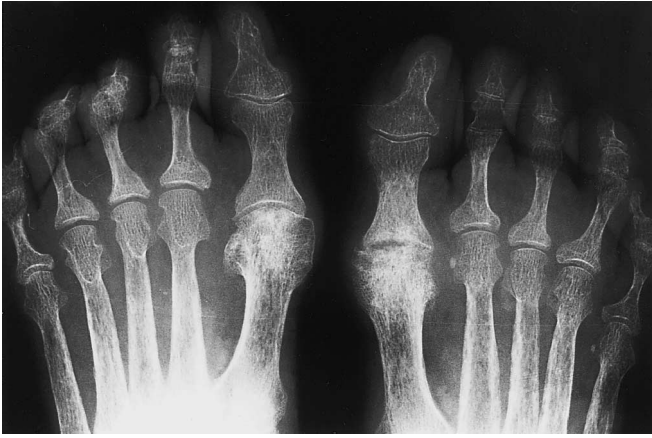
Radiographic findings of renal osteodystrophy: renal osteodystrophy is considered to be a mixture of osteopenia, osteomalacia and osteosclerosis caused by chronic renal failure. This figure highlights blurred osteopenia of the spongy bone as the main feature of osteomalacia
